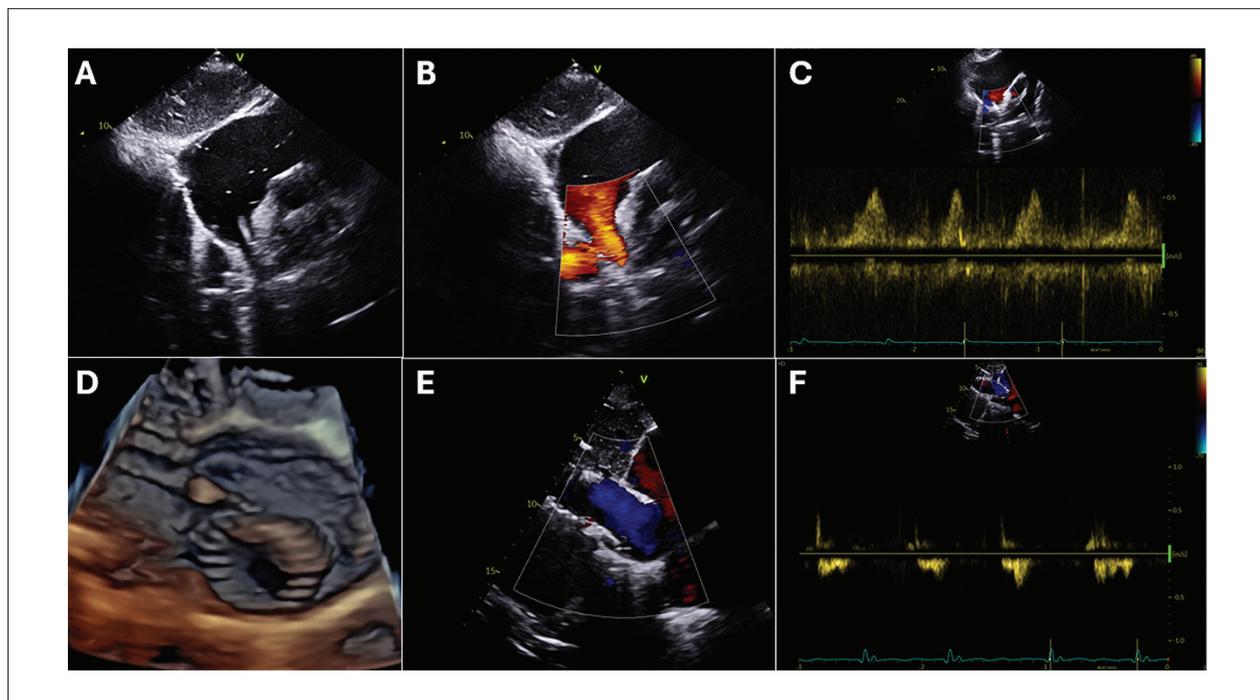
Evaluation of the TricValve after implantation by TTE. (A) Visualization of the superior caval prosthesis through the subcostal window. (B) Color Doppler with antegrade flow through the superior caval prosthesis. (C) Pulsed Doppler of the flow through the superior caval prosthesis. (D) 3D image of the inferior caval prosthesis demonstrating the 1.5 cm protrusion into the right atrium. (E) Color Doppler with antegrade flow through the inferior caval prosthesis. (F) Pulsed Doppler of the flow through the superior caval prosthesis.
